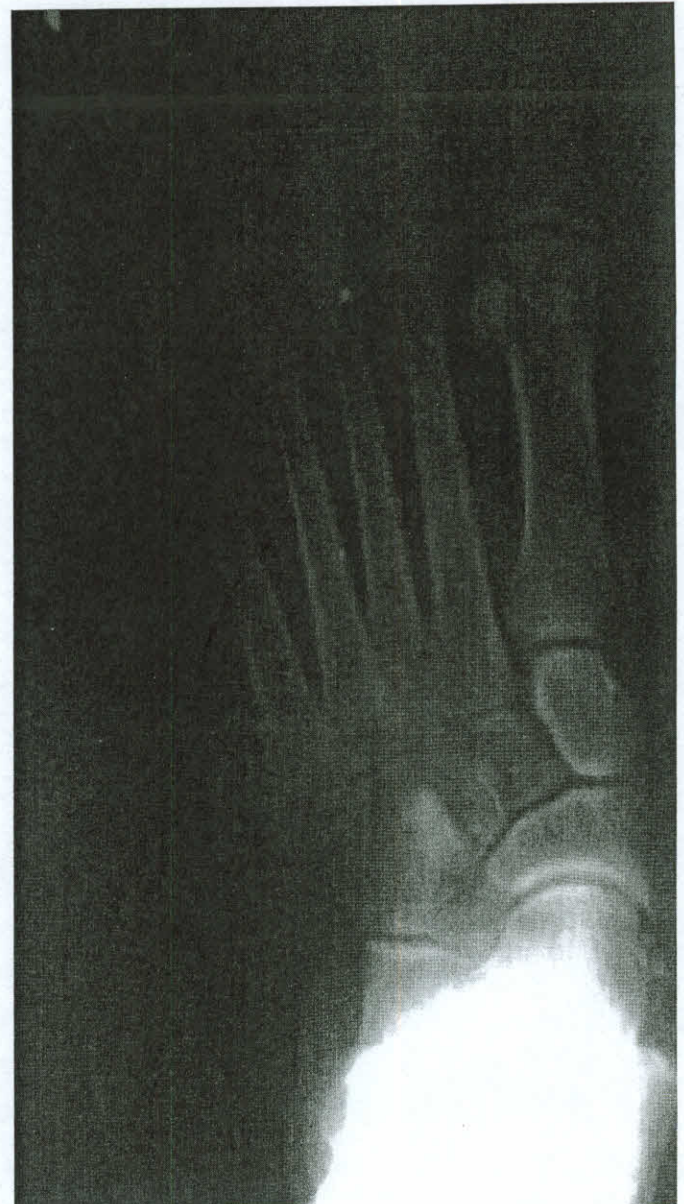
Preoperative anteroposterior radiographic view of the left foot in weight bearing.
